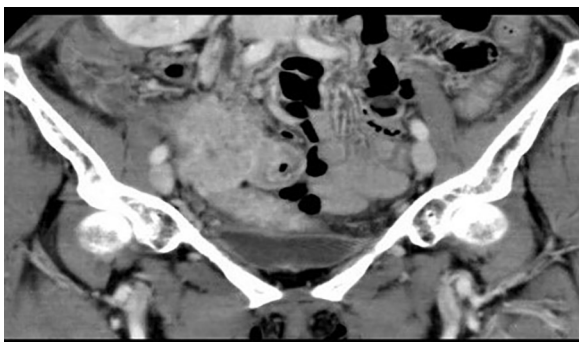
CT scan showing an extensive mass and the surrounding tissue, accompanied by a contrast effect in the abdominal cavity.
